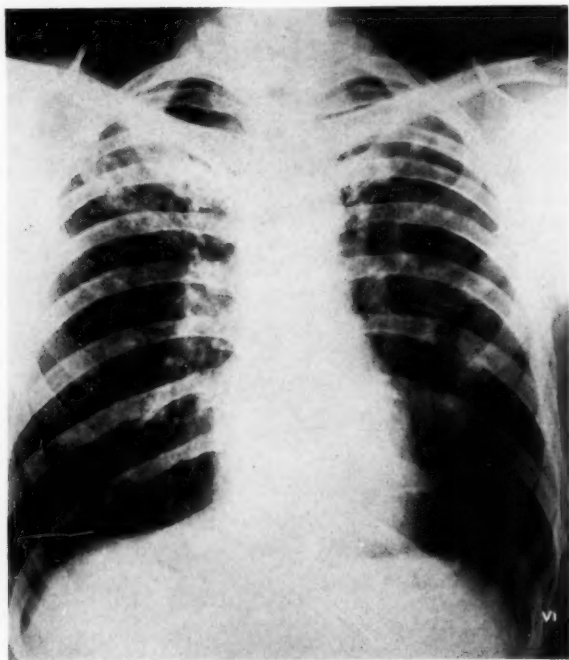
Radiograph in January 1954, with shadowing throughout both lung fields.
